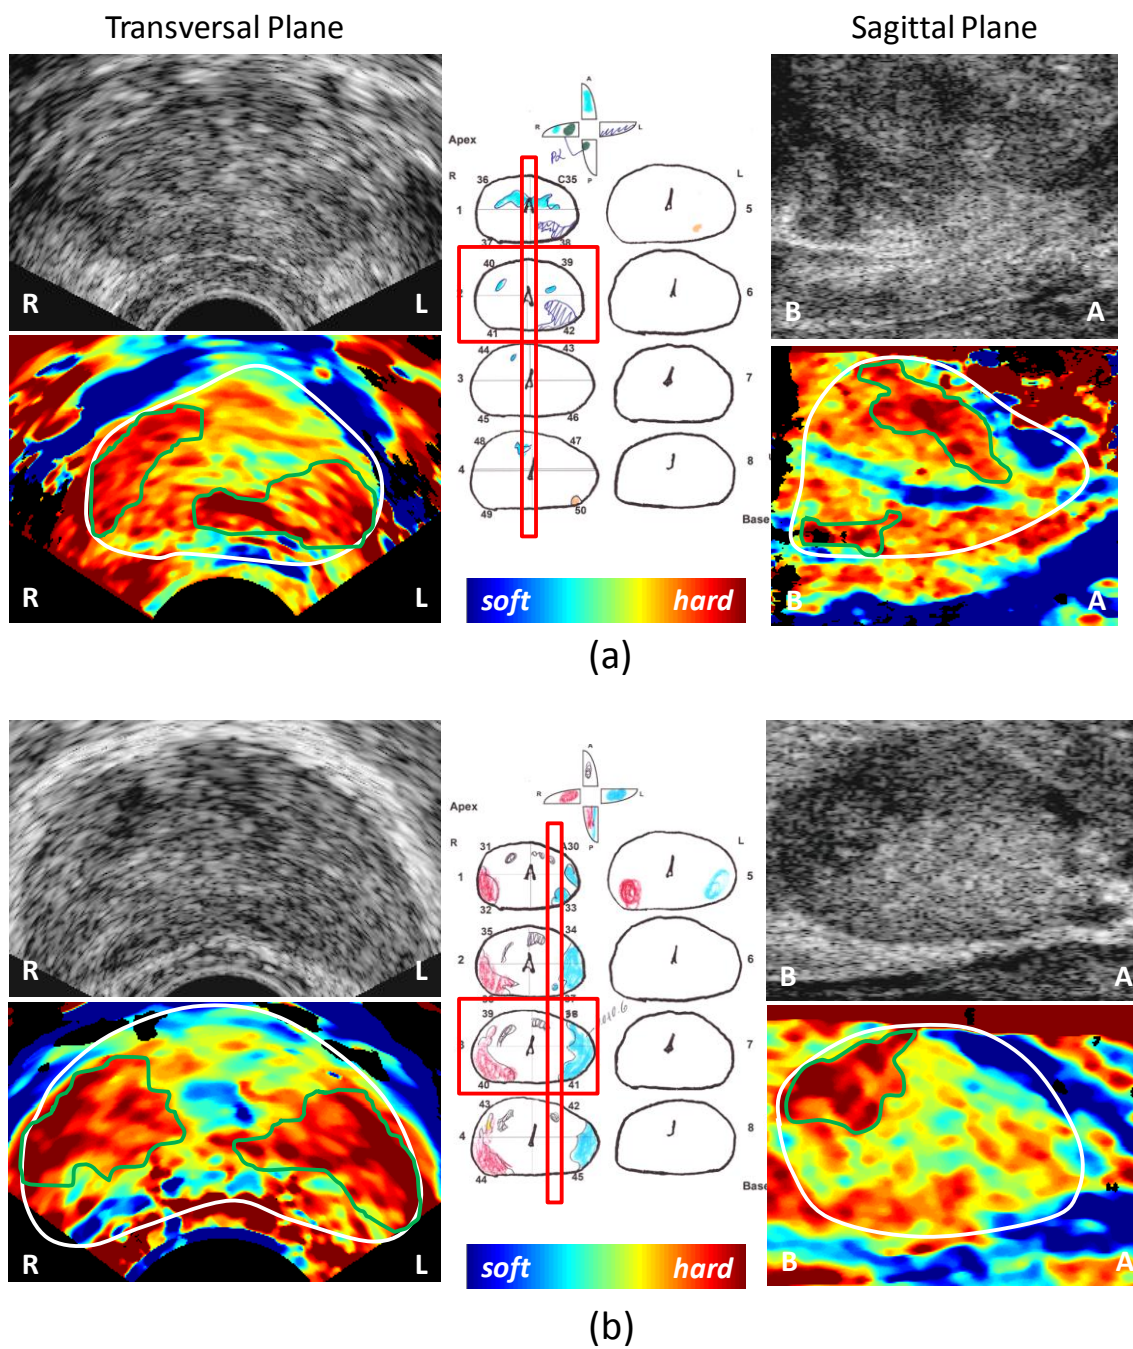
Ultrasound and elasticity images of transversal and sagittal planes obtained from (a) case #8 and (b) case #11. Pathological analysis is also shown here to compare it with elasticity imaging results.
